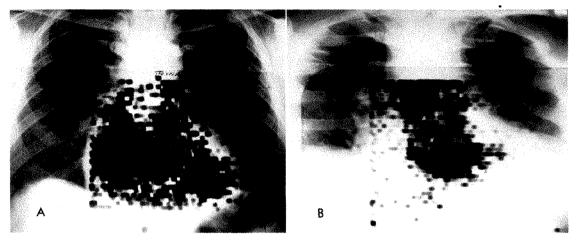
(A) Photoscan of heart superimposed on chest roentgenogram. The large heart shadow is completely filled with darkened film which represents the distribution of I<sup>31</sup> RISA in the heart's chambers. Anatomic diagnosis was cardiomegaly secondary to congenital interventricular septal defect. (B) Photoscan of heart superimposed on chest roentgenogram. The large heart shadow contrasts vividly with the darkened film which represents ventricular size. Anatomic diagnosis was pericardial effusion secondary to Hodgkin's disease.
